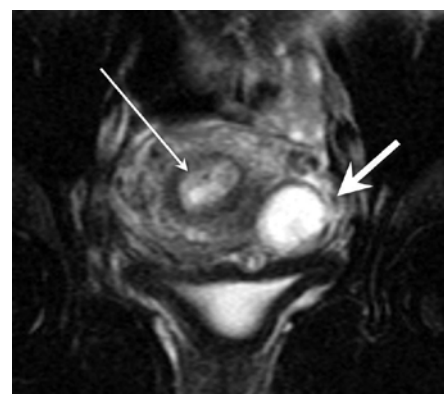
Coronal MRI T2 view of scar ectopic (thick arrow), distinct from endometrial cavity (thin arrow).
